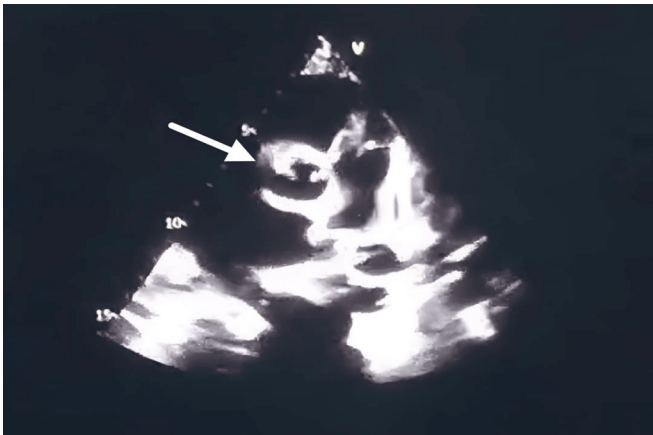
Parasternal short axis view with a focus on the pulmonary valve revealing a vegetation
